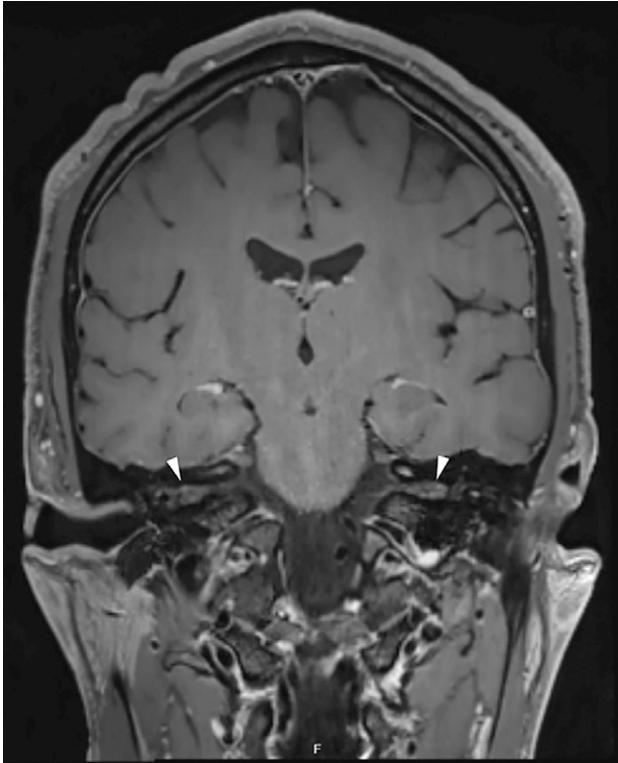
Coronal slice of a T1 fat saturated magnetic resonance imaging. White arrows demonstrate bilateral nodularity of the internal acoustic meatus (a canal within the petrous portion of the temporal bone, which contains the facial nerve, the vestibulocochlear nerve, the vestibular ganglion, and the labyrinthine artery).
